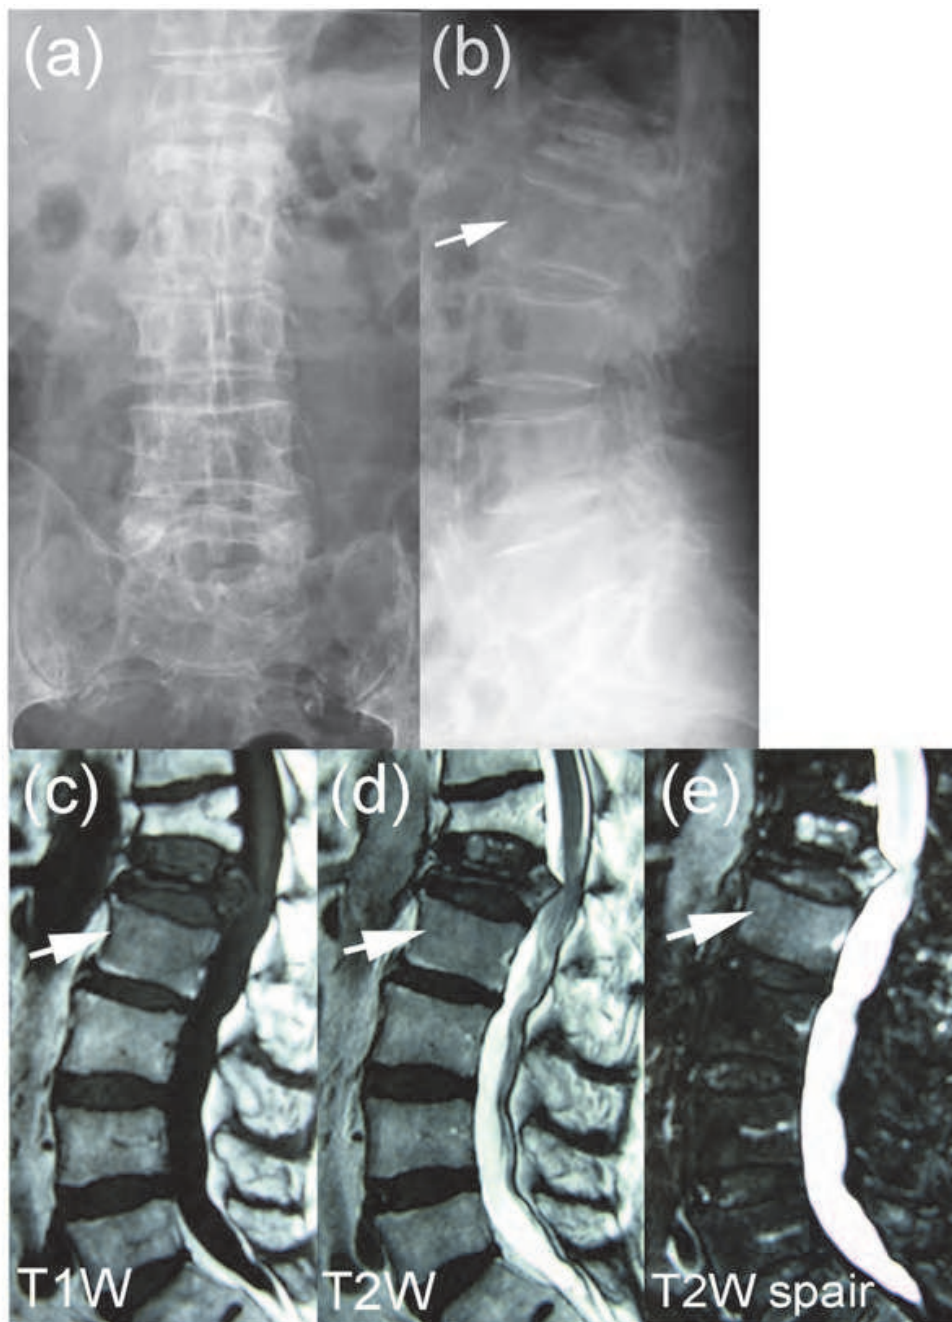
Radiographic study (a, b) and magnetic resonance imaging (c, d, e) of lumbar spine in a patient with SAPHO syndrome accompanied by acrodermatitis continua of Hallopeau. Bone marrow edema at the second lumbar vertebral body (arrow) is compatible with sterile osteitis.
